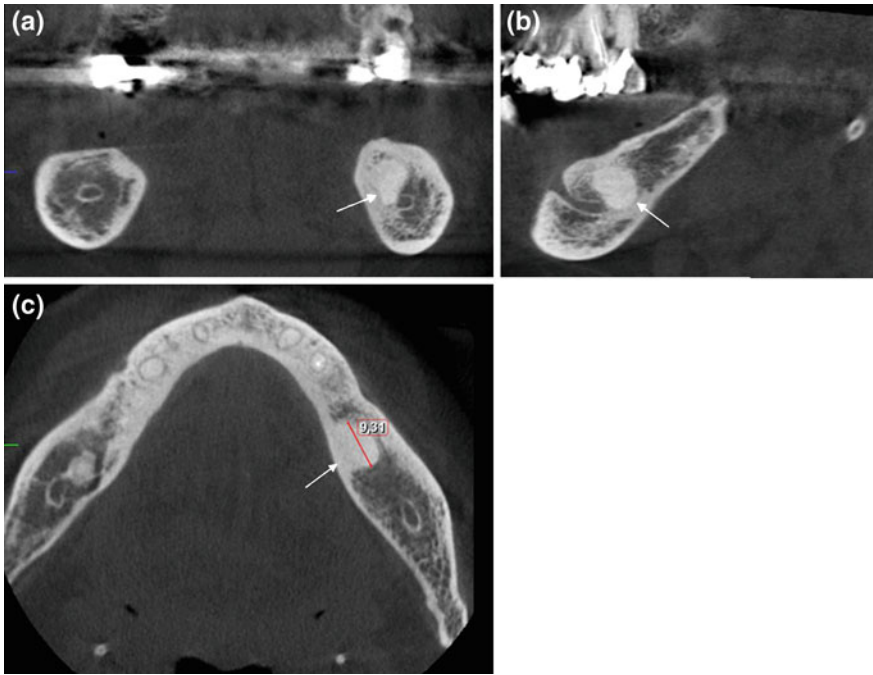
CBCT coronal (a), sagittal (b) and axial (c) scans showing in the region of left mandibular molars an ovalar well-defined lesion (*arrows*) more radiopaque than the precedent one with maximum diameter of 9 mm. Note there are not alteration of cortical bone. The radiological signs directs to a florid cemento-osseous dysplasia
